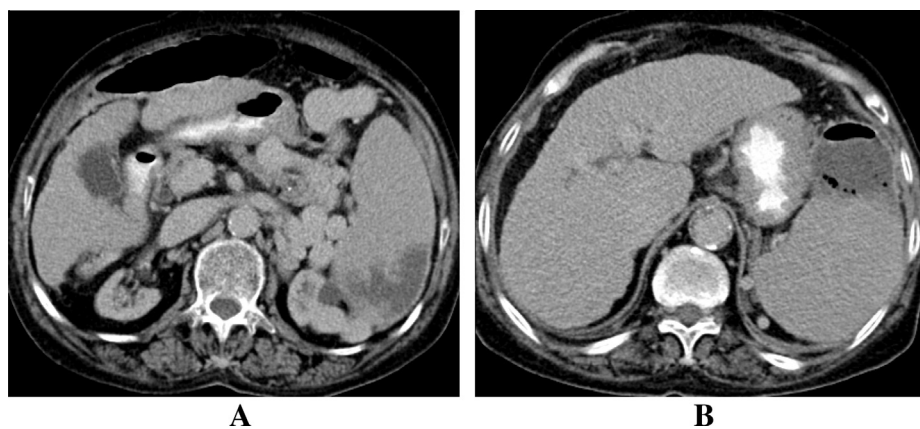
Non contrast CT scan in two different SCA patients showing splenic infarct (A), seen as capsular based irregular triangular shaped hypodense patch (Arrow) and splenic abscess (B), seen as splenic cystic swelling showing air fluid levels (arrow).
